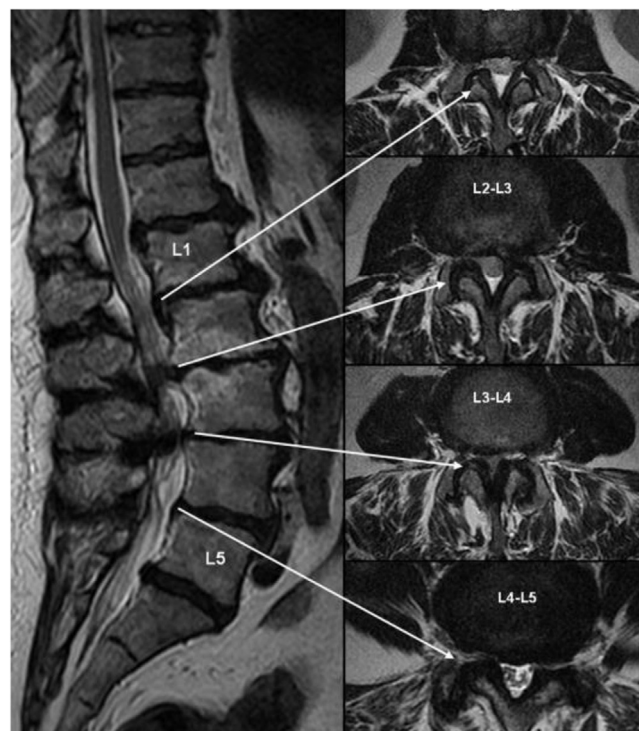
Axial and sagittal T2-weighted MRI in a patient with degenerative lumbar canal stenosis.
